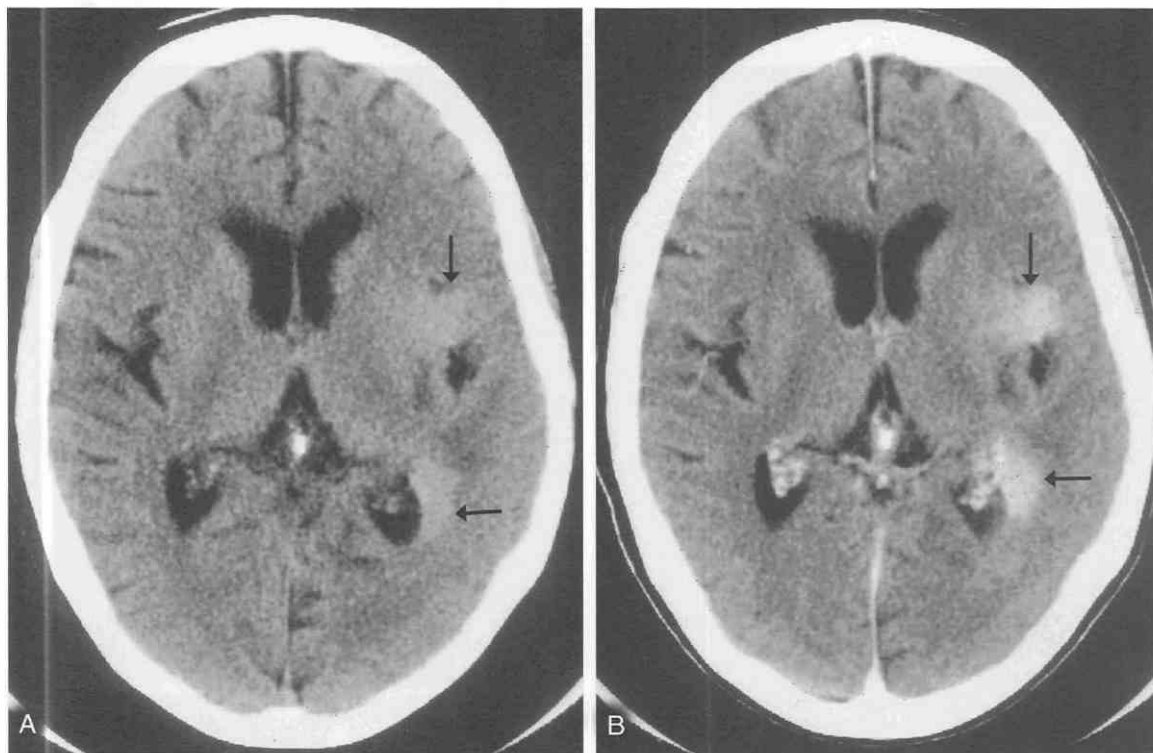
Anaplastic astrocytoma, left frontotemporal. Axial CT images prior to (A) and following (B) the intravenous administration of iodinated contrast medium. On the noncontrast image (A), patchy areas of hyperdensity (arrows) are noted on both sides of the left sylvian fissure, involving the medial (insular) and lateral (temporal) aspects. There is mild mass effect on the lateral margin of the atrium of the left lateral ventricle by the posterior extension of this tumor (posterior arrow). Note the ill defined diffuse hypodensity extending between and surrounding the hyperdense regions; this likely represents a mixture of infiltrating tumor cells and reactive edema. B, On the postcontrast image, there is diffuse contrast enhancement of the previously hyperdense regions (arrows). Note that the enhancement reaches the ependymal surface of the left atrium. There is no evidence of intratumoral necrosis.
